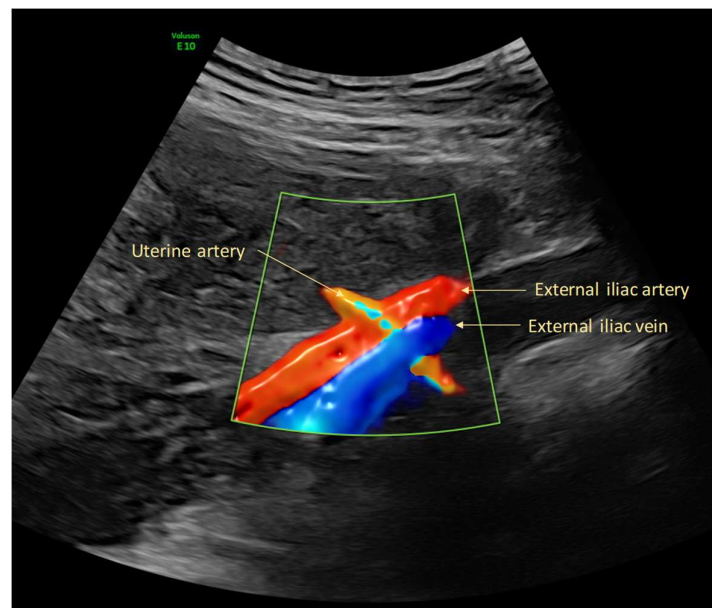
Colour flow mapping with contemporary ultrasound equipment demonstrating the uterine artery crossing the external iliac vessels. Image produced by D Paoletti.
